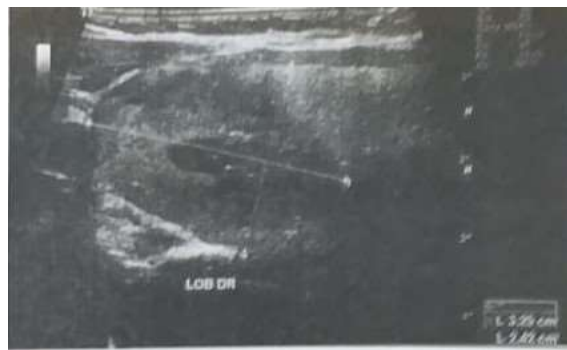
Thyroid ultrasound showing a 4 cm right intrathyroidal nodule.
